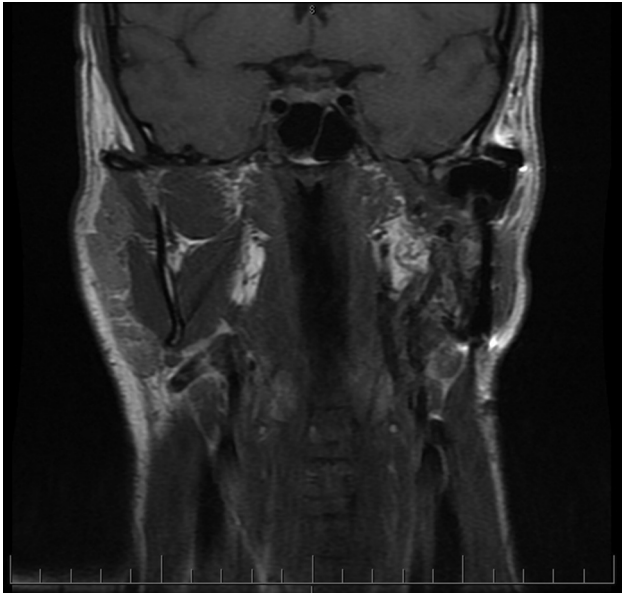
Postoperative imaging. Magnetic resonance imaging coronal view (T1-weighted image post-gadolinium contrast) showing left ascending ramus and temporomandibular joint prosthesis, with no evidence of recurrence.
